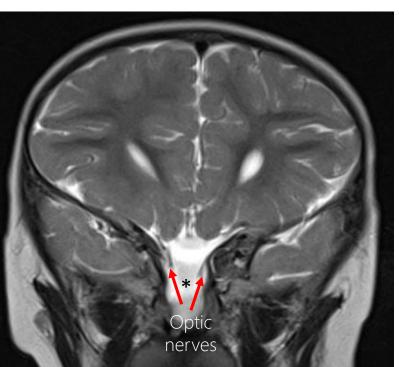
Anterior encephalocele mostly containing CSF (asterisk) as seen on a coronal T2-weighted image. Anterior skull defect with herniated optic nerves.
